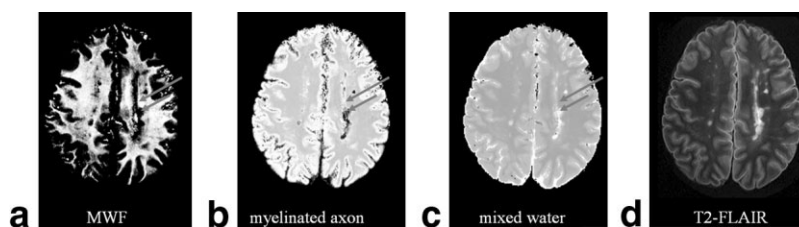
The maps of the 3 pools (a–c) show excellent delineation of MS lesions, WM, and GM. The  $T_2$ -FLAIR image acquired at the same slice location is shown in (d) for the location of the lesions. At a region indicated by the long arrow, the decreased intensity in (a) and increased intensity in (b) suggest the dominance of the demyelination process. At a central region of a lesion indicated by a short arrow, the decreased intensity in both (a) and (b) suggest the occurrence of both demyelination and axonal damage.
